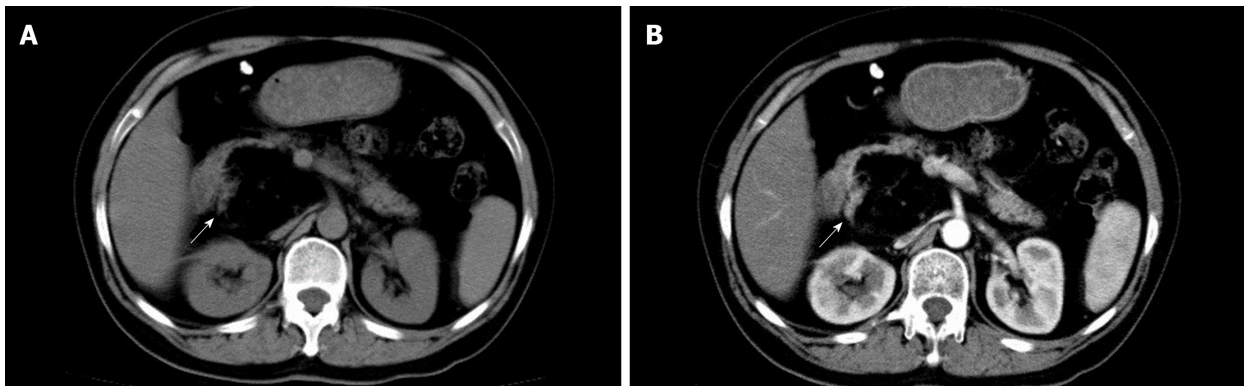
Computed tomography scans before treatment. A: Non-contrast abdominal computed tomography (CT) showed a 6.4 cm × 6.0 cm, nearly circular, heterogeneous lesion, owning indistinct borders, located in the head of the pancreas. B: Contrast-enhanced CT imaging indicated that the fat containing tumor (-109 ± 19.2 HU in the tumor and 47.9 ± 14.9 HU in the liver) had a few fibroreticular septa within it, and the surrounding parenchyma of the mass could be slightly enhanced (arrow).
